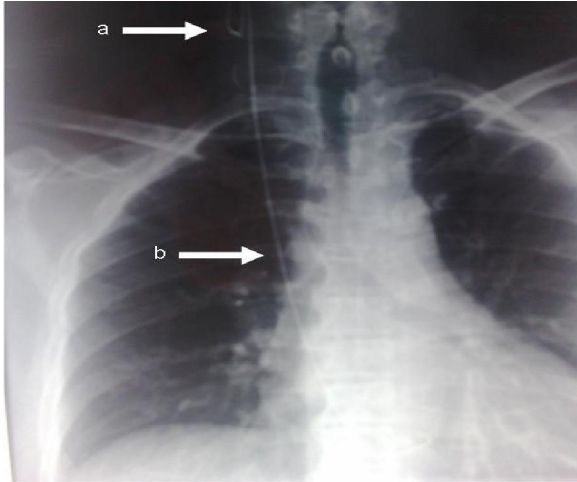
X-Ray showing the knot formation (a) and the presence of the distal guide inside the vascular structures and right heart (b).
